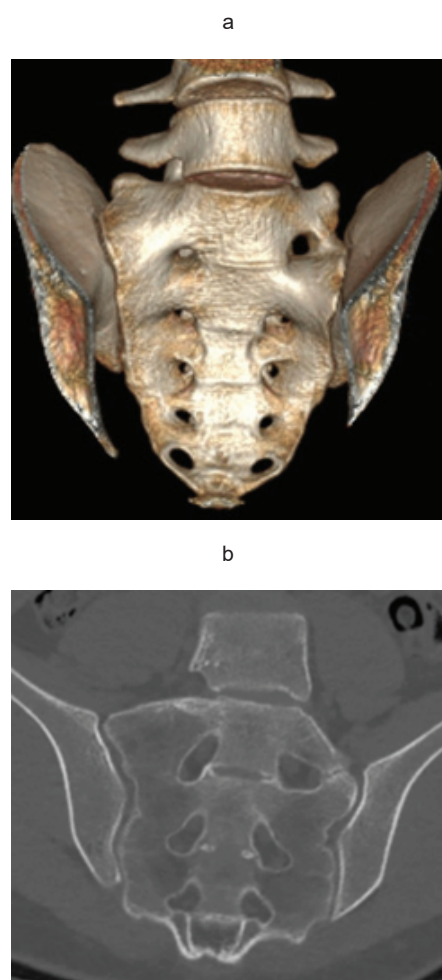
CT scans of the sacrum of a 29-year-old patient. Right-sided bone block (a), left-sided synchondrosis (b) between two cranial vertebrae
